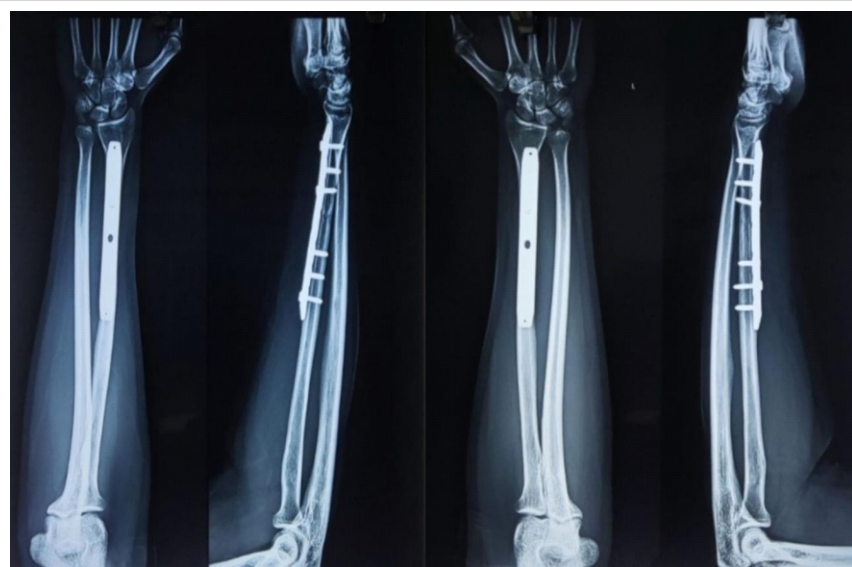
6 months post-operative anteroposterior and lateral X-ray views of bilateral forearm. There is a normal union process of the radial fractures and no evidence of distal radioulnar joint instability.
